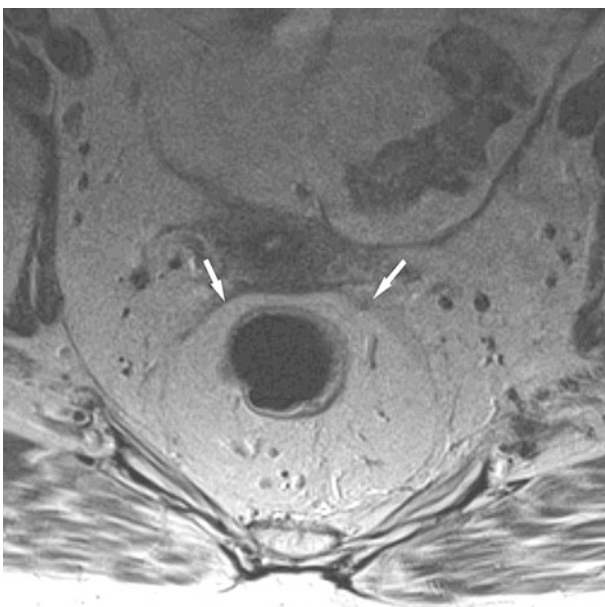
The urogenital septum (or Denonvilliers Fascia) is shown as hypointense bandlike structure on this axial T2-weighted image (arrows)
